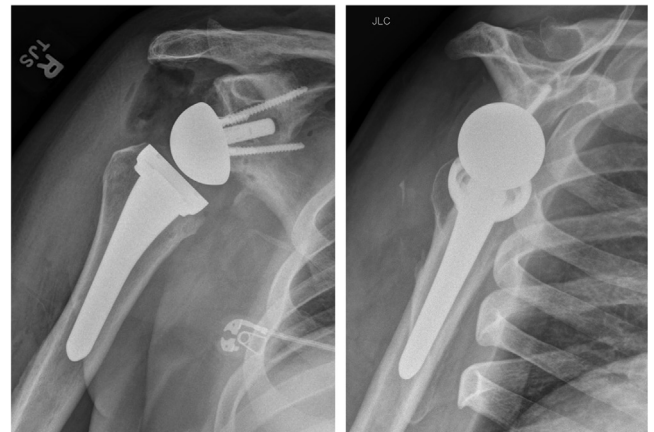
Postoperative AP and scapula Y radiographs demonstrate well-positioned reverse total shoulder arthroplasty with glenoid autograft augmentation.
